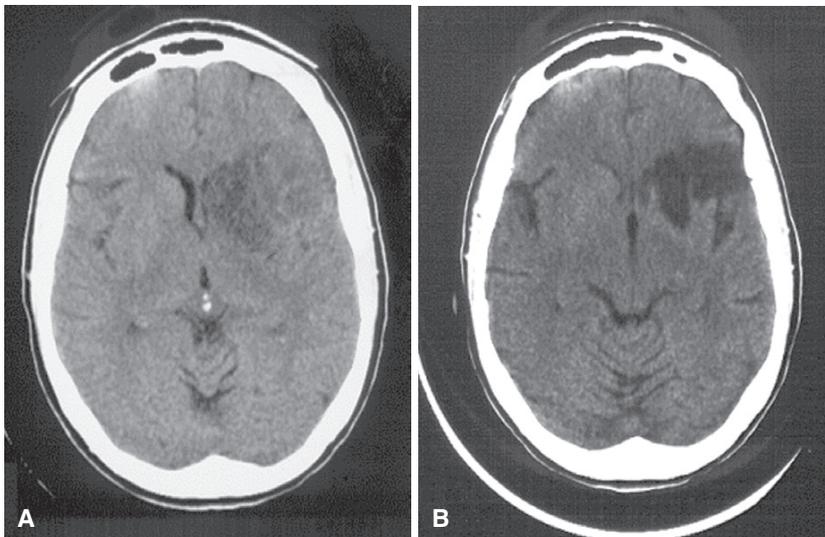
Computed tomographic imaging. A, A computed tomography (CT) scan of a patient with a left hemisphere infarction 6 to 24 hours after the onset of symptoms shows a hypodense area in the basal ganglia region and compression of the frontal horn of the lateral ventricle. B, A CT scan shows the chronic infarction 1 year later; atrophy and loss of tissue volume are visible. (Courtesy of Gregory W. Albers, Stanford University, Stanford, Calif.)
